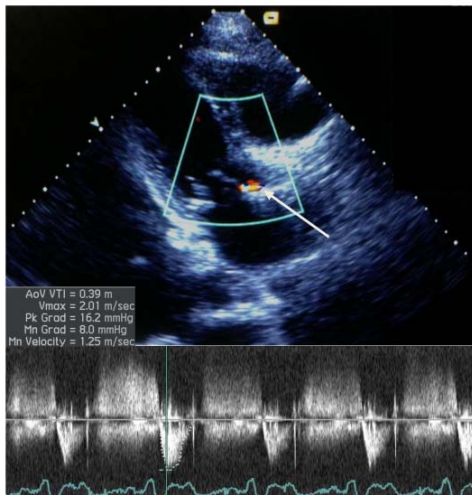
Transthoracic echocardiography – gradient across the CoreValve and trivial paravalvular regurgitation (arrow) after the transcatheter aortic valve implantation procedure.
